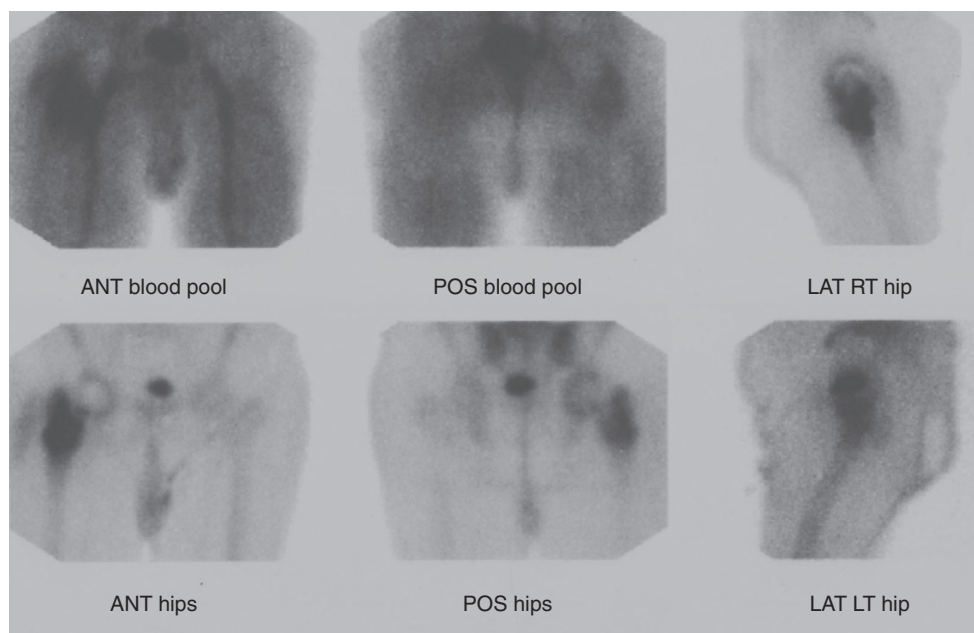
This bone scan shows increased radiotracer uptake at the proximal femur. The patient presented with activity-related thigh pain 1 year after primary cementless total hip arthroplasty. History, physical examination, and conventional radiographs suggested failure of osseointegration. At the time of surgery the femoral component was found to be grossly loose.
